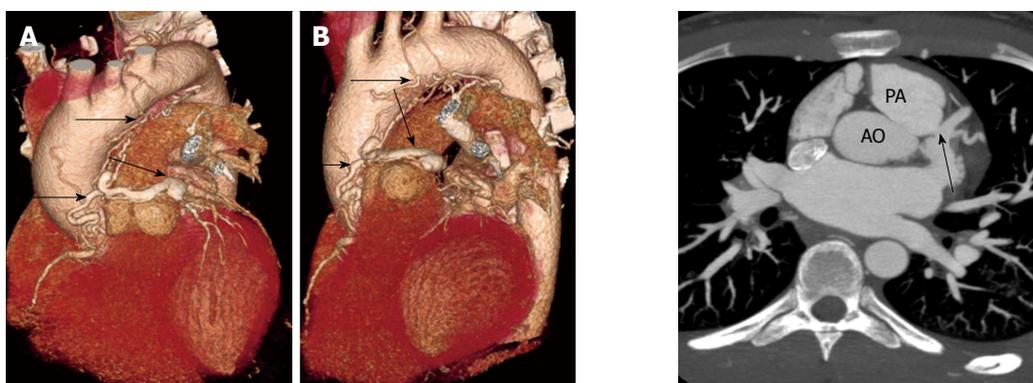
Complex coronary artery fistula. A and B: 3D volume rendered coronary computed tomography angiography shows an arterial-arterial fistula originating from the proximal right coronary artery and 1st diagonal branch, which terminates in the pulmonary artery. The plexus has an aneurysmal segment that wraps around the anterior aspect of the main pulmonary artery. There is direct communication between the aneurysmal segment and the leftward aspect of the proximal MPA. Also, there are multiple smaller branches around the aortic root, MPA, ascending aorta, and transverse arch. A branch originating from the aortic arch continuous with a small 1.8-cm contrast-filled cavity adjacent to the aortic arch, between the trachea and aortic arch.
